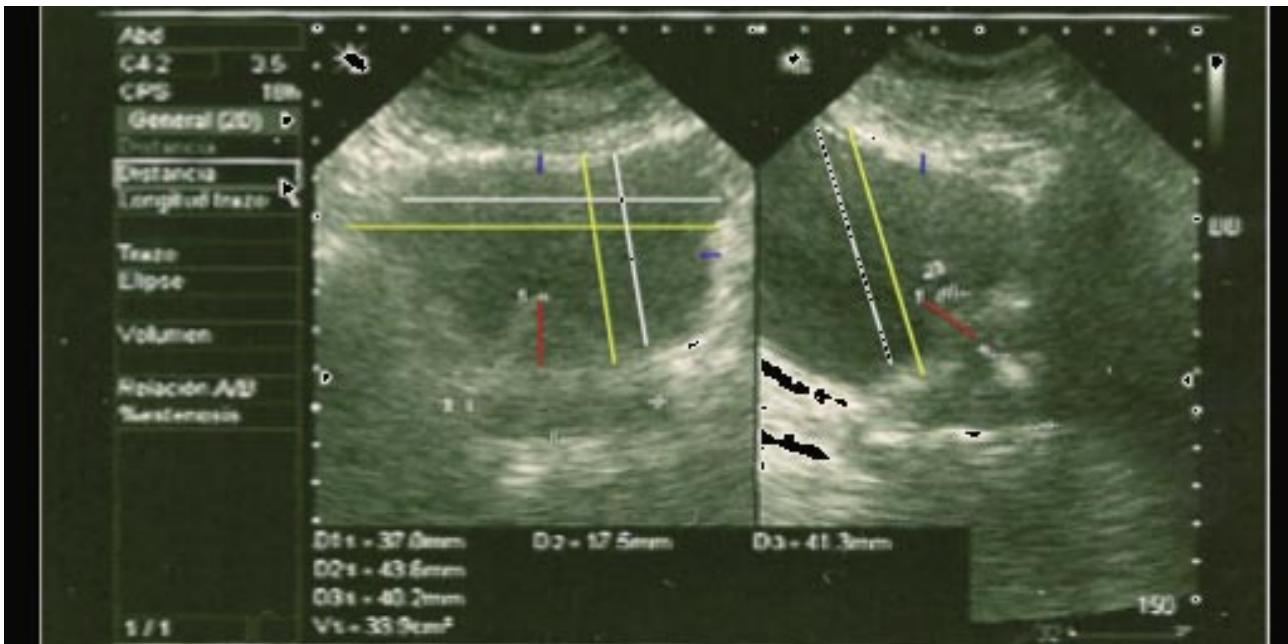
Abdominal ultrasound.
